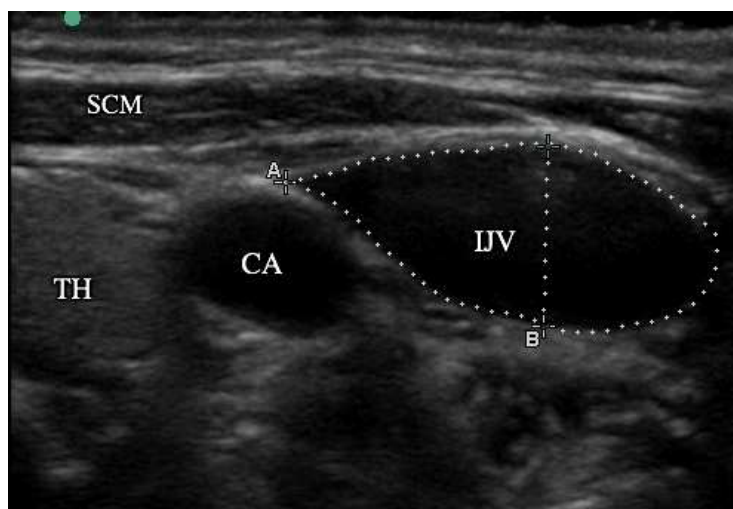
Ultrasound visualisation of *vena jugularis interna dextra* and carotid artery (Ševčuka, S. Anonymous patient. TOS. 23.11.2016.)
